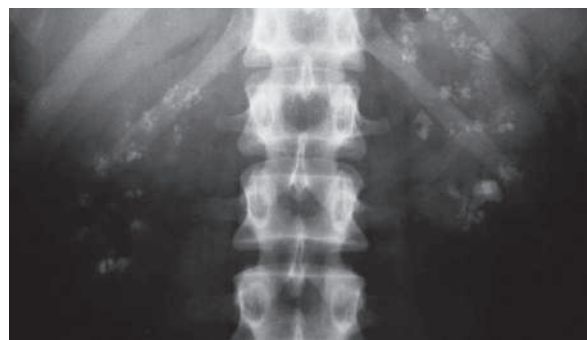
A plain radiograph of the kidneys in a patient with medullary nephrocalcinosis shows bilateral, almost symmetrical, punctuated calcification within the renal shadow
